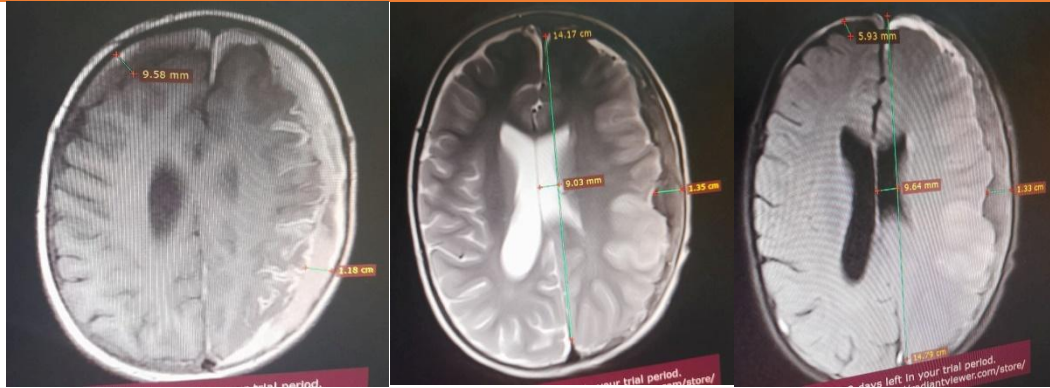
Brain MRI with contrast: Left holocerebral convexity and right occipital SDH (acute to subacute) with subfalcine herniation plus left front oparietal gyriform restriction likely postictal
